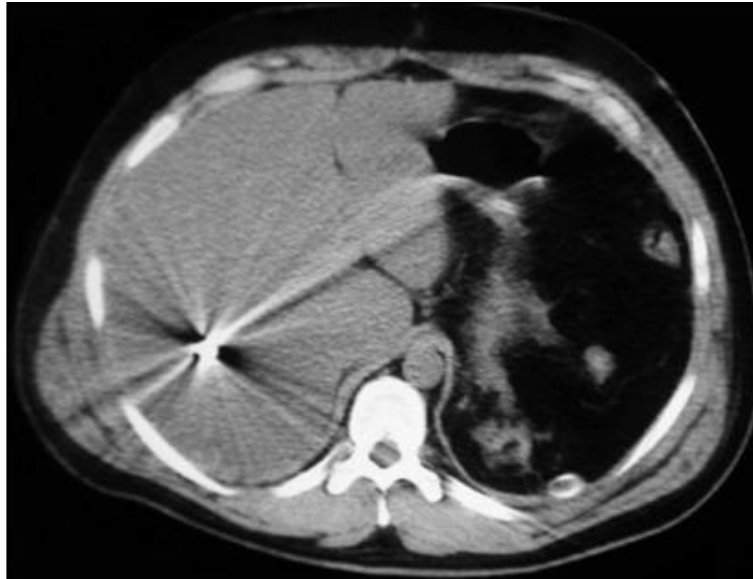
CT of abdominal organs, axial projection. Penetrating gunshot wound of the abdominal cavity (ball), wounding projectile in the right lobe of the liver.
